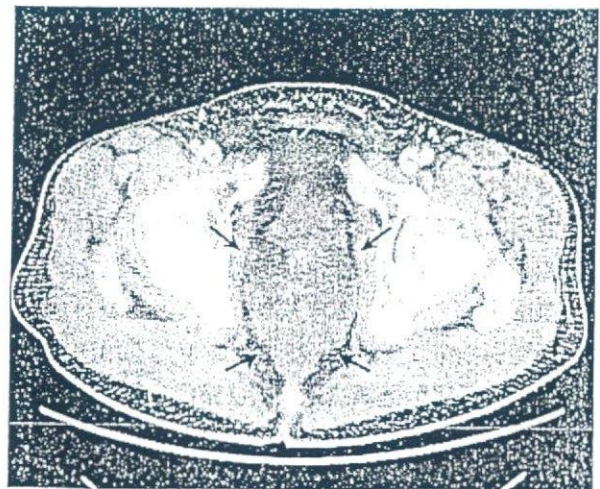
骨盤部 CT 検査: 前仙骨部に 7 cm × 7 cm の嚢胞性病変を認めた.
